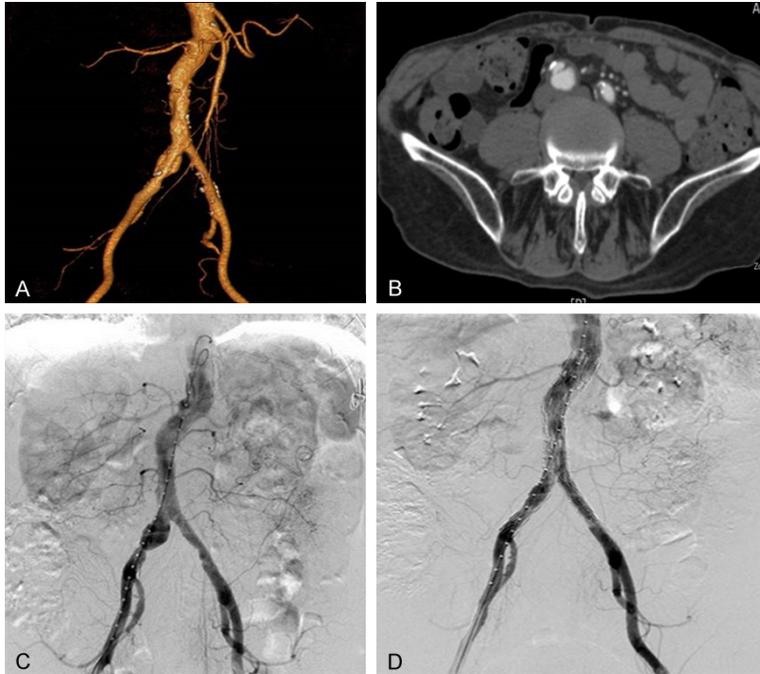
A. Pretreatment Angio-CT: MIP reconstruction of aorto-iliac vessels; B. Pretreatment Angio-CT showing a dissection-aneurysm measuring 2 cm (“double chamber” sign) at root of the right common iliac artery and normal aorta wall without mural thrombus; C. Intraoperative DSA showed aneurysmal dilatation of the proximal root of the right common iliac artery, and we decided to have endovascular treatment to repair the dissection-aneurysm using bifurcated stent graft (Lifetech Scientific Corp, Shenzhen); D. The completion angiography revealed that the stent graft was positioned well without any endo-leak and preservation of the renal arteries and both internal iliac arteries.
